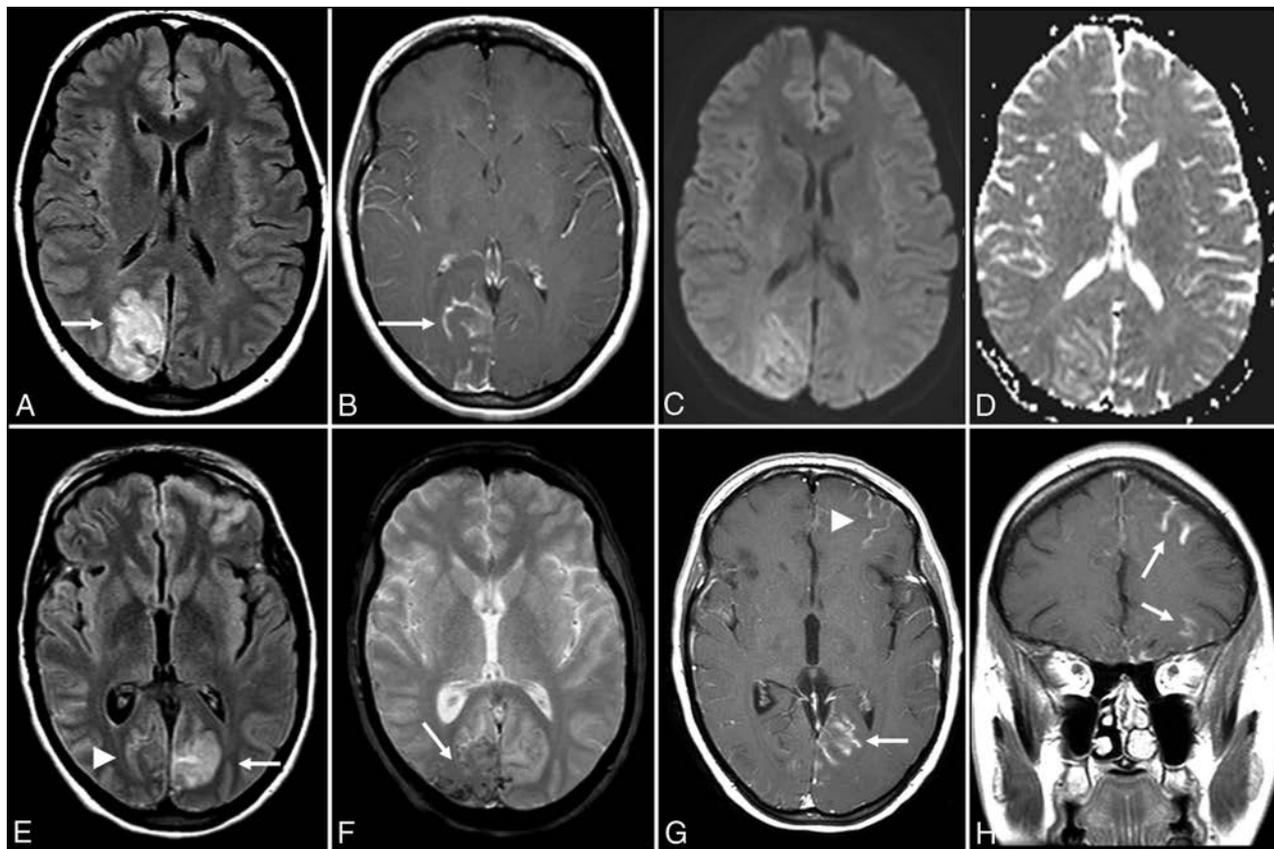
Anti-voltage-gated calcium channel encephalitis. A 39-year-old woman presented with left-sided weakness and left visual field deficits with subsequent development of encephalopathy and seizures. Initial MR imaging of the brain (A–D) demonstrates multifocal T2-FLAIR hyperintense lesions in the right parieto-occipital region (A), with associated pial/sulcal enhancement (B) and mild cortical restricted diffusion and T2 shine-through within the subcortical white matter on DWI (C) and the corresponding ADC map (D). Follow-up MR imaging of the brain performed 34 days later (E–H) demonstrates decreased T2-FLAIR hyperintensity (E) with cortical laminar necrosis and petechial hemorrhage (F) at the original lesion, with progressive development on subsequent examinations of similar cortical lesions in the contralateral frontal, parietal, and occipital lobes (E–H).
